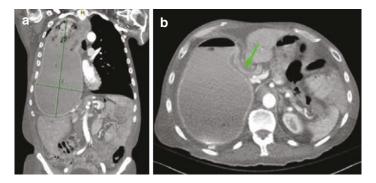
CT scan demonstrating a gastric conduit outlet obstruction. Cranial view (a), shows the stomach filling the majority of the right chest with mass effect directing the diaphragm and liver caudad. There is an outlet obstruction caused by angulation of the duodenum entering the abdomen through the hiatus (b, arrow)
